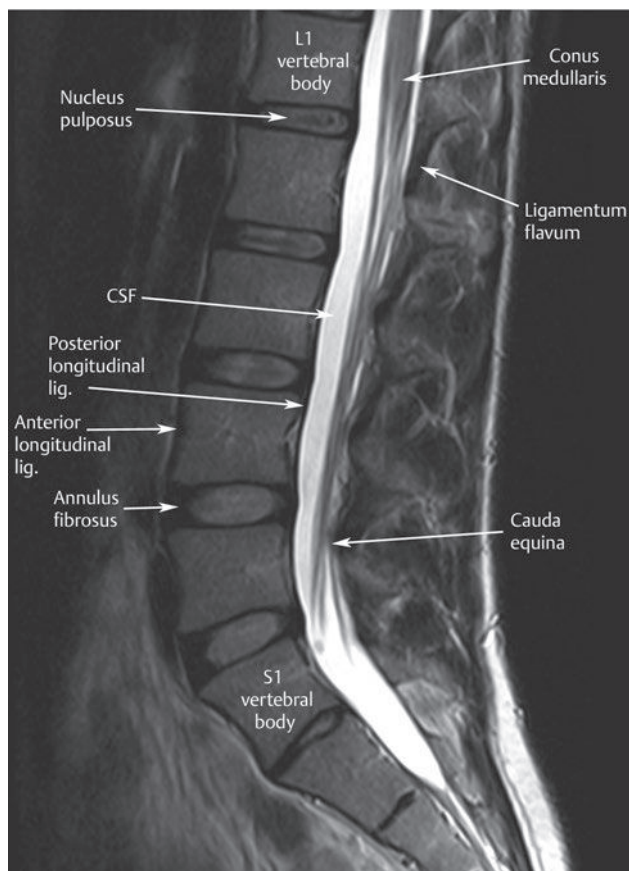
A midline sagittal T2-weighted image of the lumbar spine. Note that the spinal cord is seen in its entirety; CSF is seen anterior and posterior to the spinal cord; and the vertebral bodies and sacrum are seen in profile.[†]
